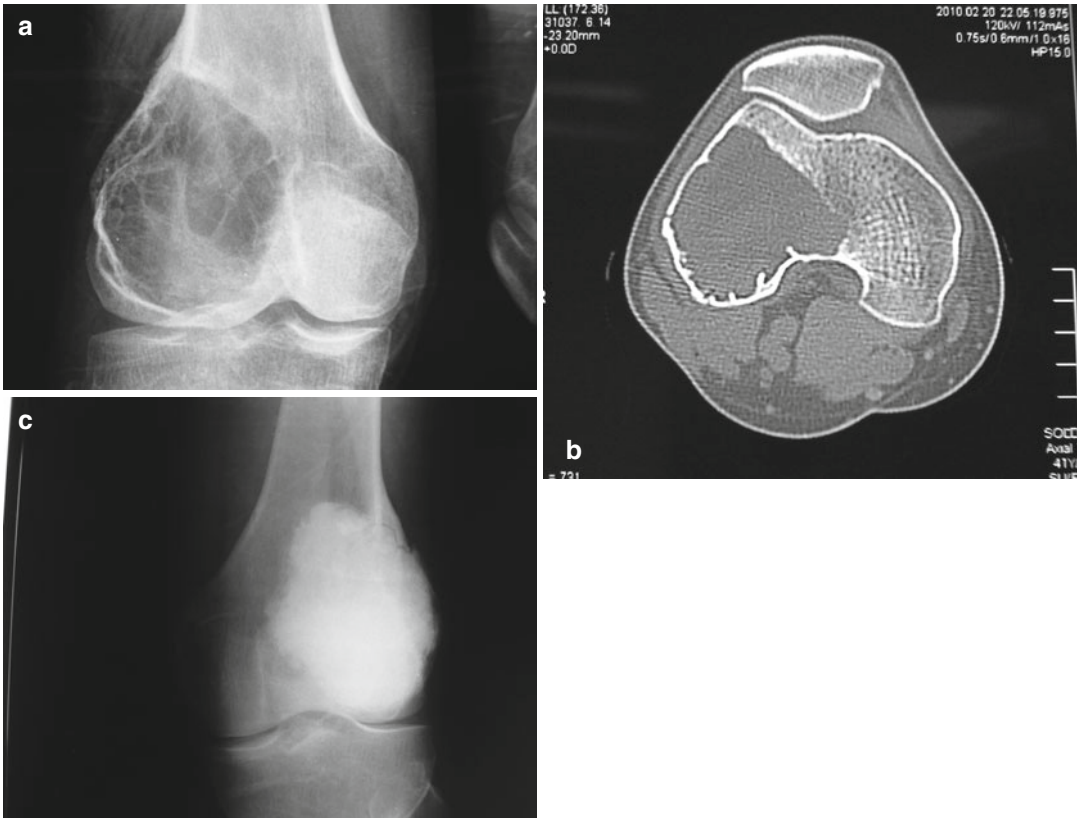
Giant cell tumor. (a) Lytic lesion is located eccentrically at the epiphysometaphyseal region of distal femur. (b) Cortex remained intact as seen on CT imaging. (c) Extended curettage and cementation was performed
